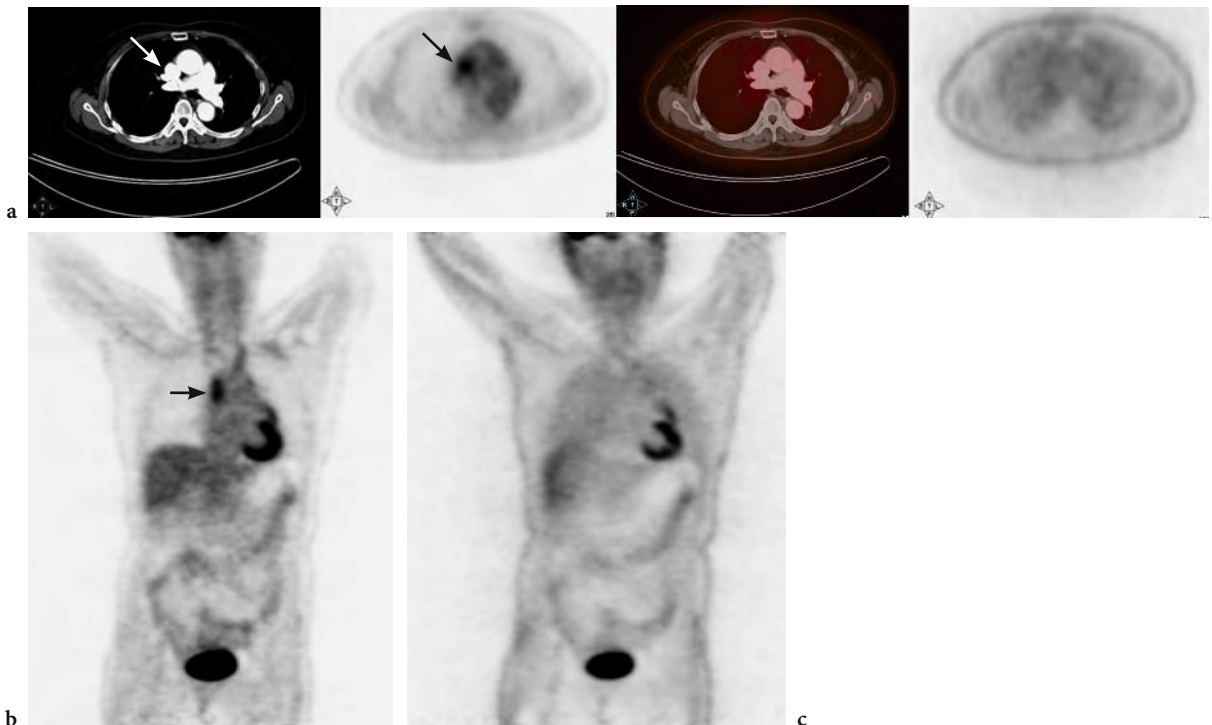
a Same patient as in Fig. 13.1 with similar layout. Axial images at the level of the superior vena cava. Note the hot spot on PET (*black arrow* on second panel from left), corresponding to contrast on CT (*white arrow*, left panel). The uncorrected PET image is normal in this region (*right panel*). b Coronal PET images show that the hot focus in the superior vena cava region (*black arrow*) is induced by attenuation correction. c The uncorrected coronal image shows normal FDG uptake in this region of the thorax
